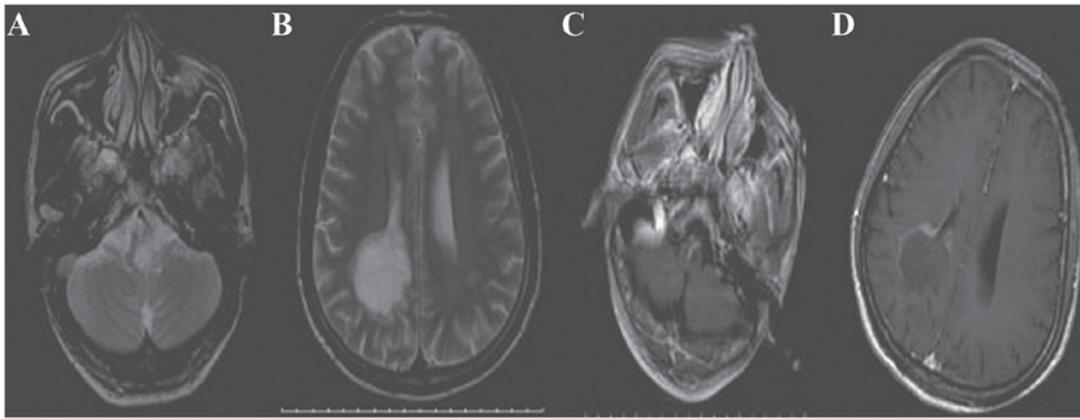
(A) Head magnetic resonance imaging (MRI) showing a flaky hyperintense T2 signal with unclear edges in the medulla oblongata. (B) The signal was strengthened after an enhancement scan. (C) Head MRI showing a flaky hyperintense T2 signal in the white matter around the posterior horn of the right lateral ventricle. (D) The lesion in the posterior horn of the right lateral ventricle appears as a low-intensity flaky signal that was only marginally strengthened after the enhancement scan.
